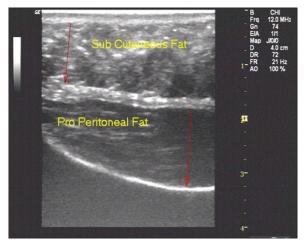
Measurement of subcutaneous fat by ultrasound
